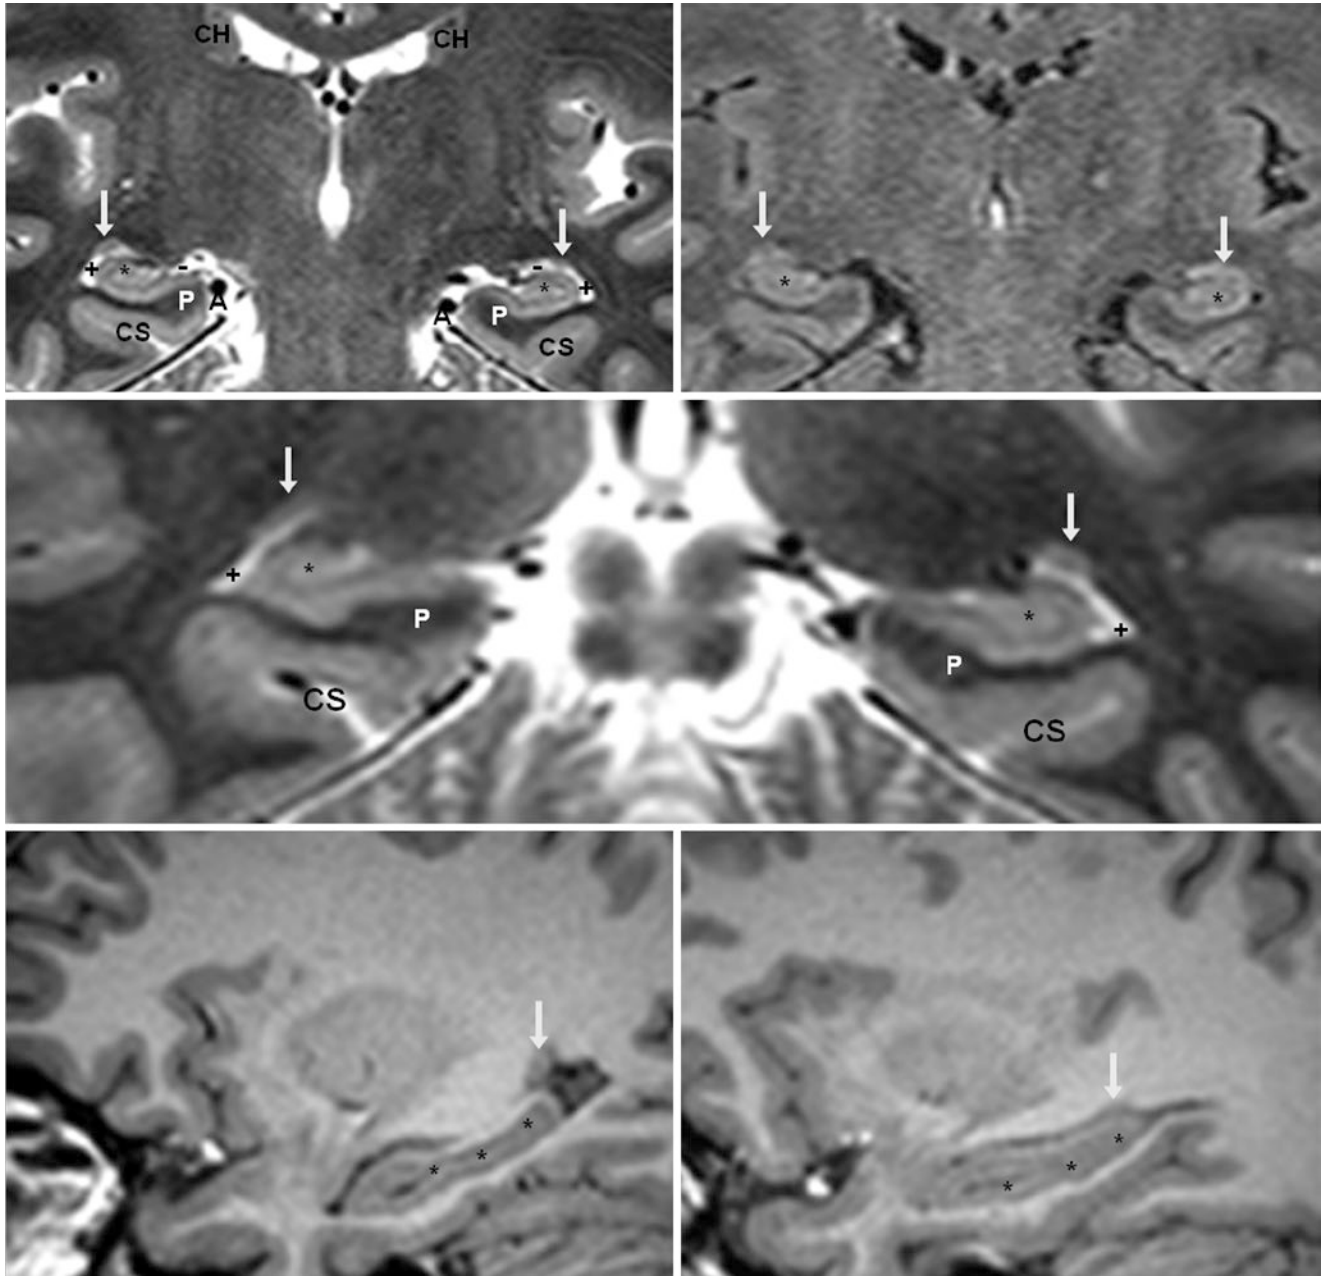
A 31 year old with seizures had a negative 3 T MRI evaluation. On a coronal T2WI through the hippocampus (*top left*), a structure with gray matter signal intensity representing the caudate tail (*arrows*) is seen on the right side better than the left. It is not well visualized on coregistered coronal FLAIR (*top right*). A coronal T2WI located more posteriorly (*middle*) also depicts the caudate tails, which
